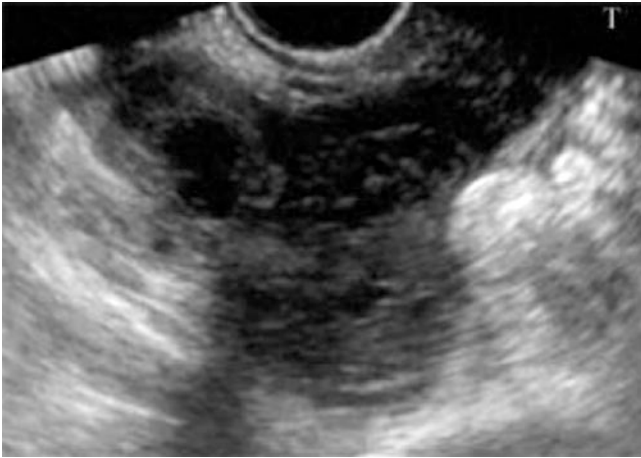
Acute pelvic parametritis. On the eighth day after delivery, the patient has pain in the lower abdomen, with increased body temperature and increased white blood cells. Sonogram shows the indistinguishable uterus contour and surrounding irregular hypoechoic tissue
